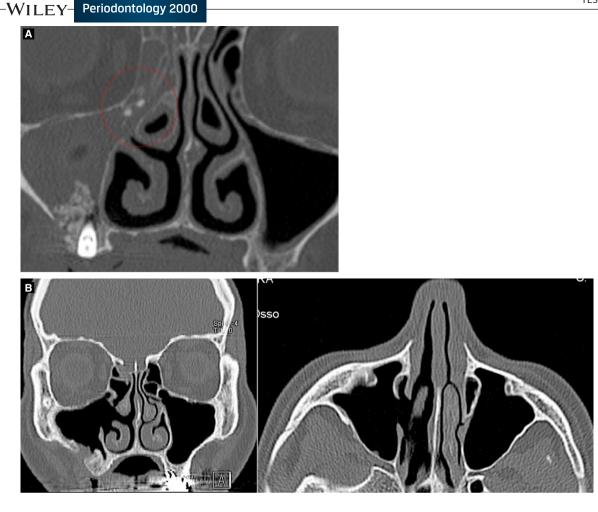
A, Cone beam computed tomography depicts graft material migration to the ostium. Clinical exam reveals localized tenderness, edema/swelling, fistula formation, and foul odor/taste. B, Cone beam computed tomography delineates normal/healthy sinus anatomy following functional endoscopic sinus surgery
